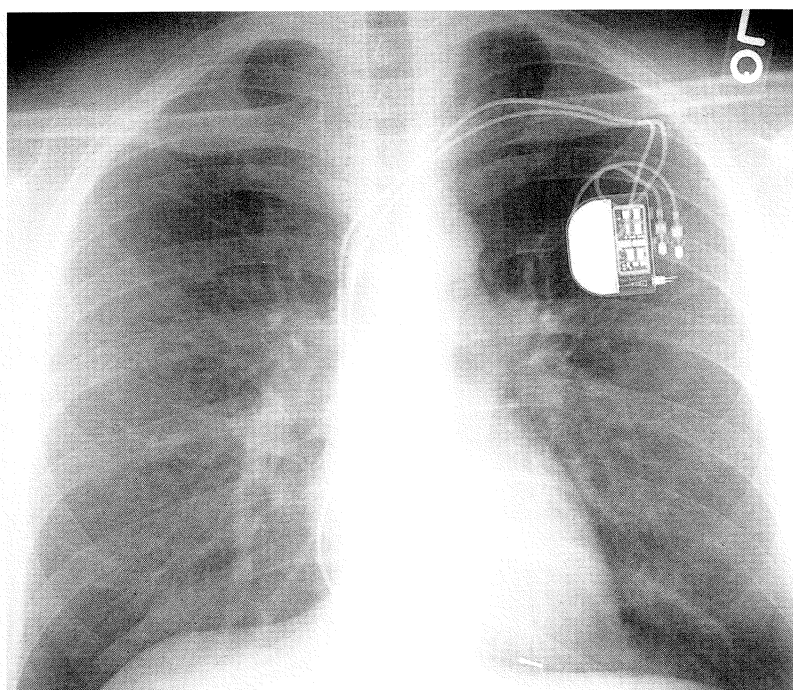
PA chest radiograph
